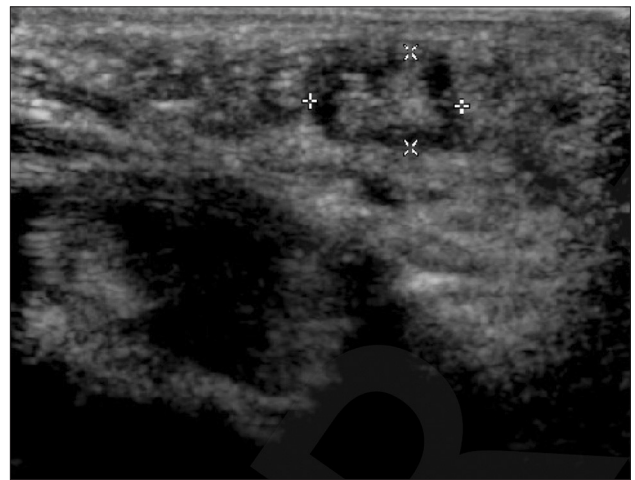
Ultrasonographic image: 0.5 cm sized isoechoic nodule.
